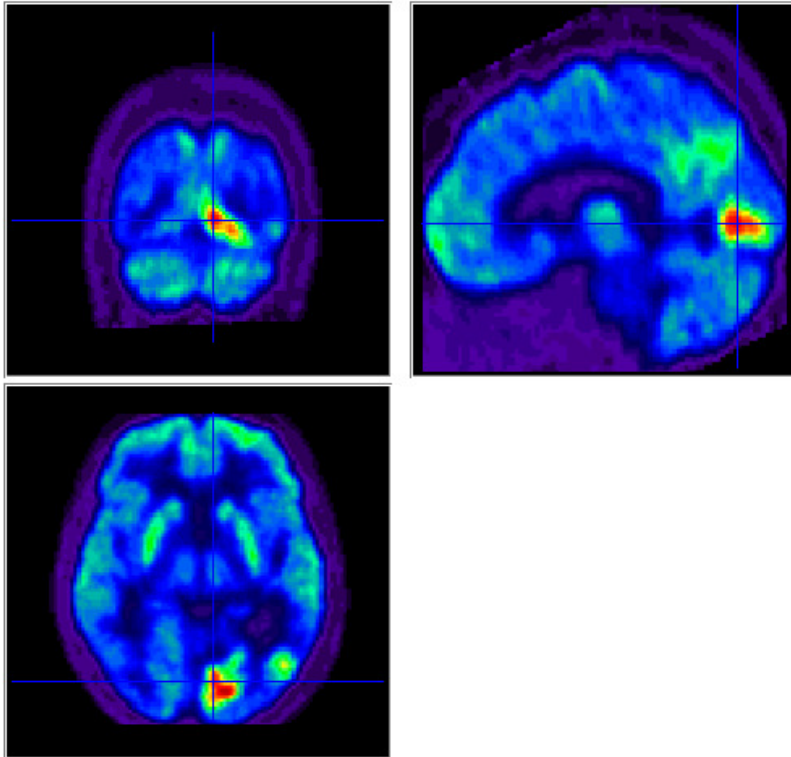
FDG-PET resulting in two hypermetabolic areas in the left temporal and occipital lobes
